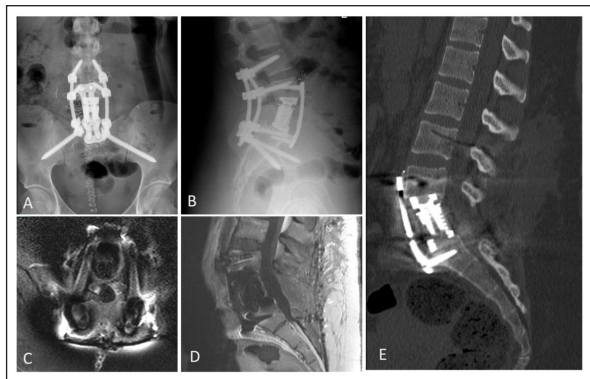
Post-operative images. (A) coronal x-ray, (B) sagittal x-ray, (C) axial contrasted T1 MRI, (D) sagittal T1 contrasted MRI and (E) sagittal CT showing satisfactory fixation and lesion resection.
